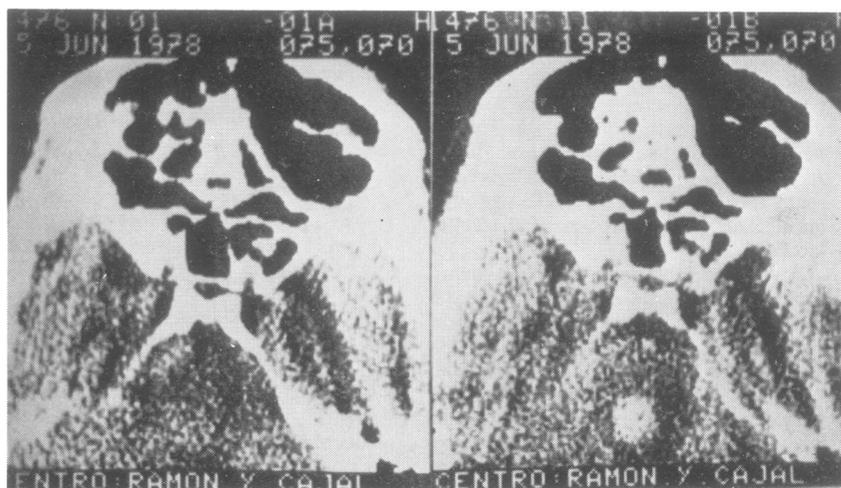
Figure CT showing enhancement of isodense pontine lesion.
